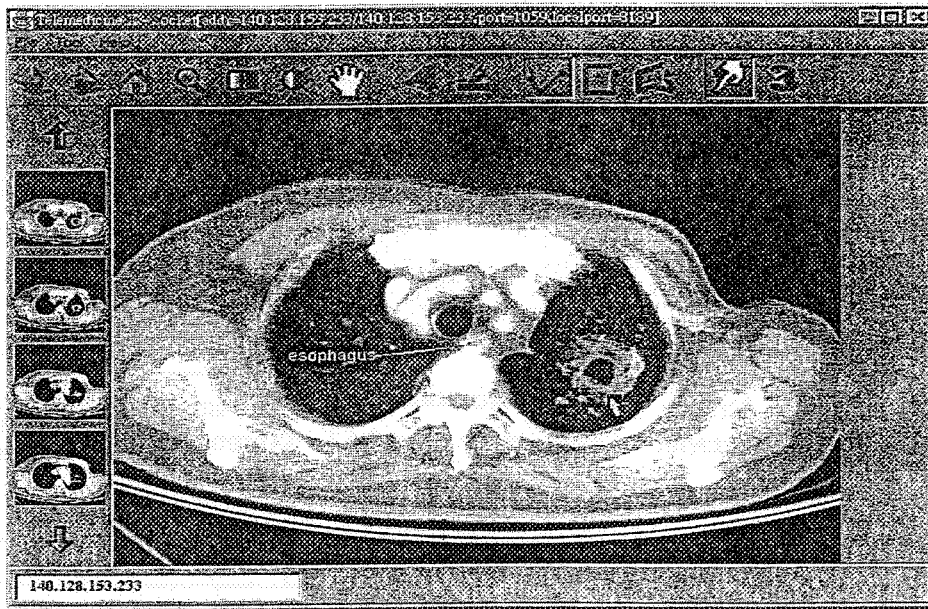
A coincided CT image of chest displayed on the monitors during consultation. The synchronous cursor or pointer is pointing to the mass lesion in the left upper lobe lung. An annotation to the conspicuous structure (esophagus) is indicated within the image.
